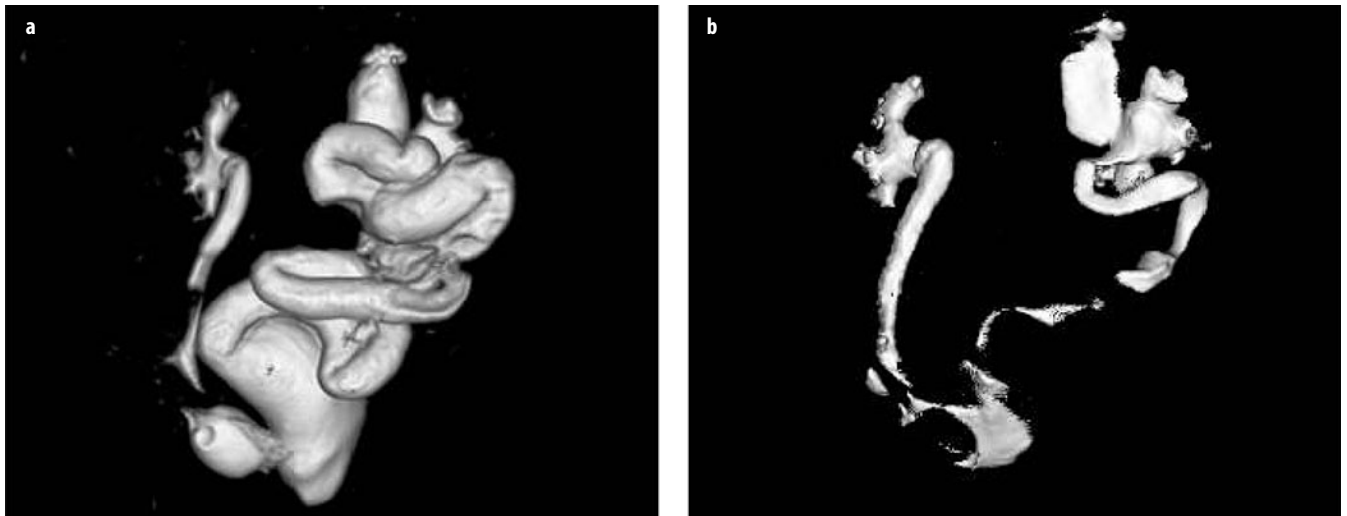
a, b. T2-weighted (a) and postcontrast T1-weighted (b) 3D magnetic resonance urograms (MRU) show the anatomy and morphology of hydronephrotic and poorly functioning systems
